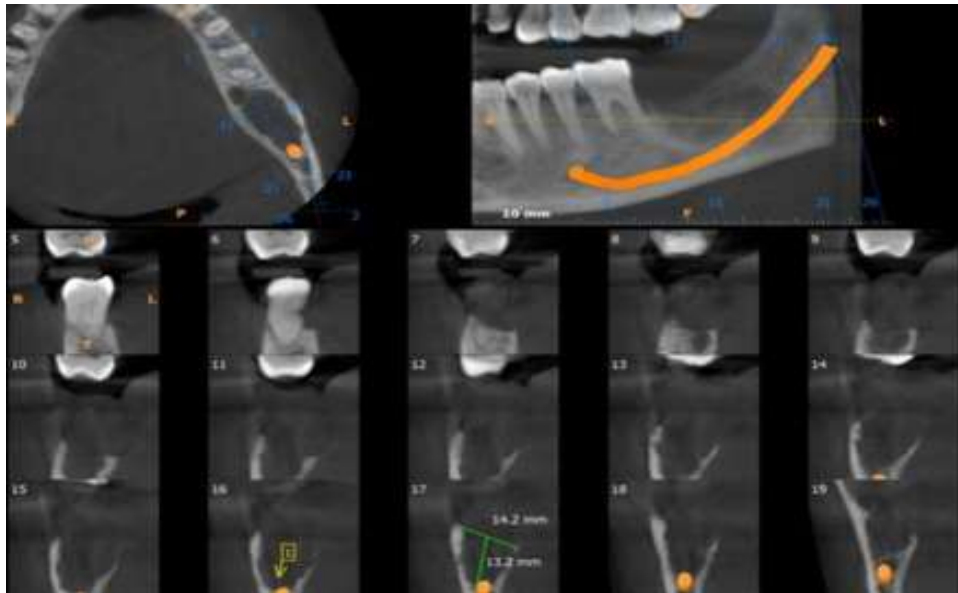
CBCT confirmed focal destruction extending from left mandibular premolar to molar region with destruction of lamina dura, part of mandibular canal wall, erosion of buccal and lingual cortex.
